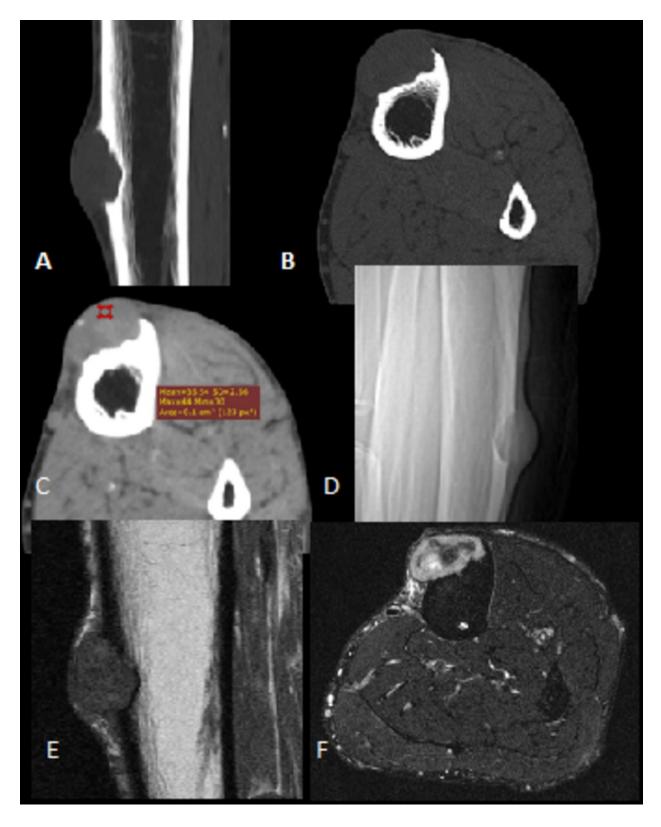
Chondromyxoid fibroma. MPR thick (A) and axial computed tomography reformations (B, C) show an eccentric well-defined lytic lesion, with chondroid matrix, and a punctate calcification in the left tibia. The computed tomography orientation scout (D) reveals an oval, well-defined, sharply marginated eccentric lytic lesion in the left
